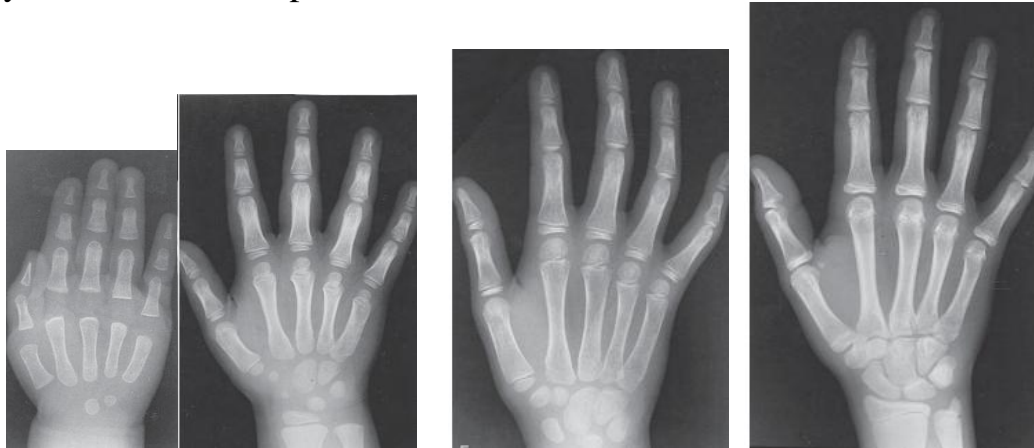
Skeletal maturation and normal development: posteroanterior radiographs of the hand and wrist. (A) Male; CA = 13 mo; (D) Female; CA = 4 yr; SA = 4 yr.
